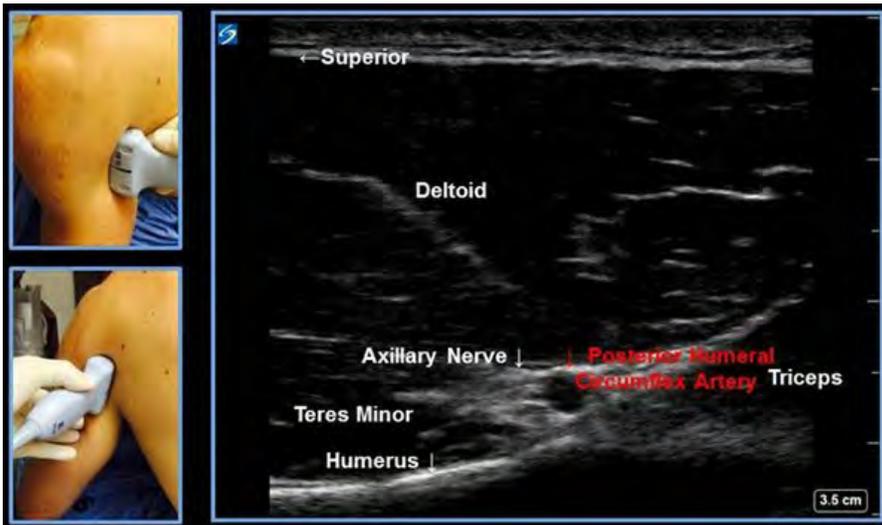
Ultrasound guided ANB. Probe orientation is parallel to humerus on posterior aspect of arm. Injection is in-plane with needle target just above posterior humeral circumflex artery.
